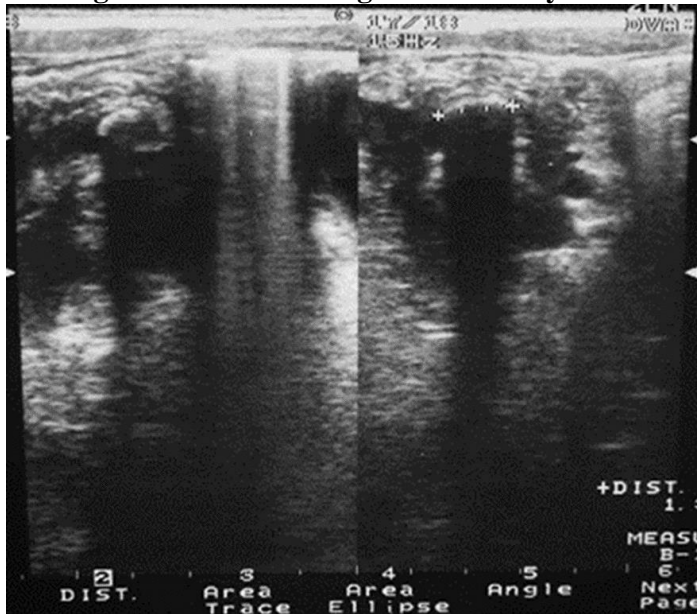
Sonogram (long & trans) showing an appendicolith with posterior acoustic shadow, within the distal end of a perforated appendix. Note moderately large peritoneal fluid posterior the Fluid distended appendix.
